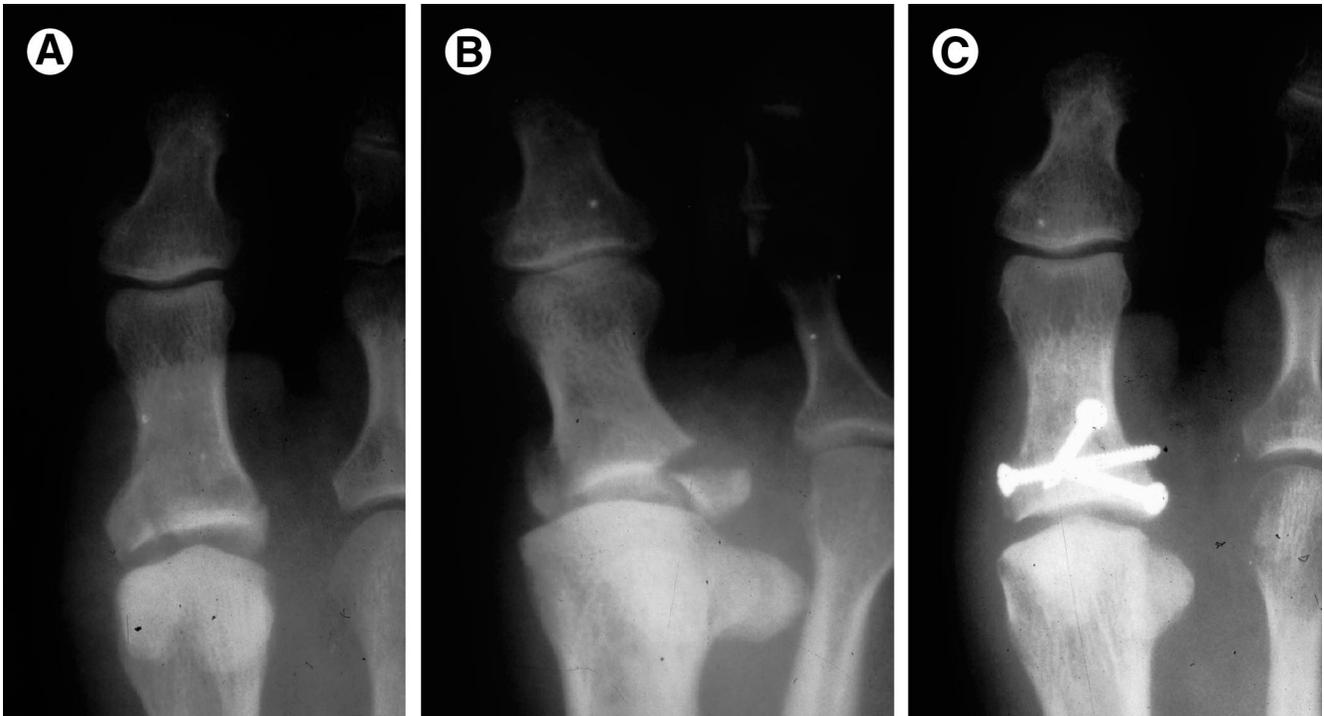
The (A) anteroposterior and (B) oblique radiographs show multiple fragments of the proximal phalangeal base, with (C) open reduction internal fixation.
